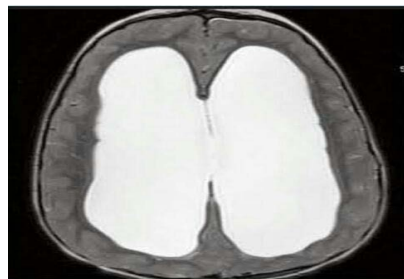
Preoperative MRI brain T2 done showing supra-tentorial triventricular hydrocephalus.
